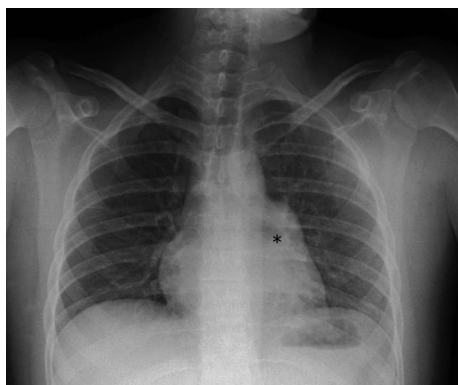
Chest radiograph. Chest radiograph showing horizontalization of the left bronchus (asterisk) initially interpreted as hilar adenopathies and later found to be secondary to herniation of the left atrial appendage through the pericardial defect.
